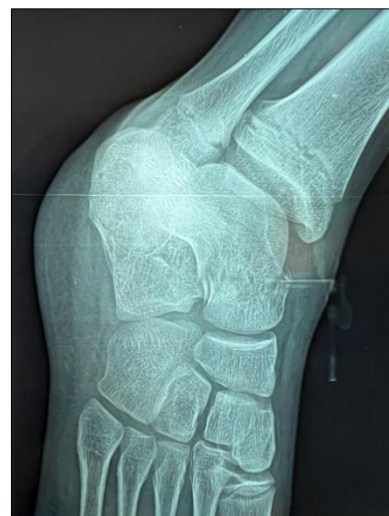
Standard ankle X-ray showing talus fracture
